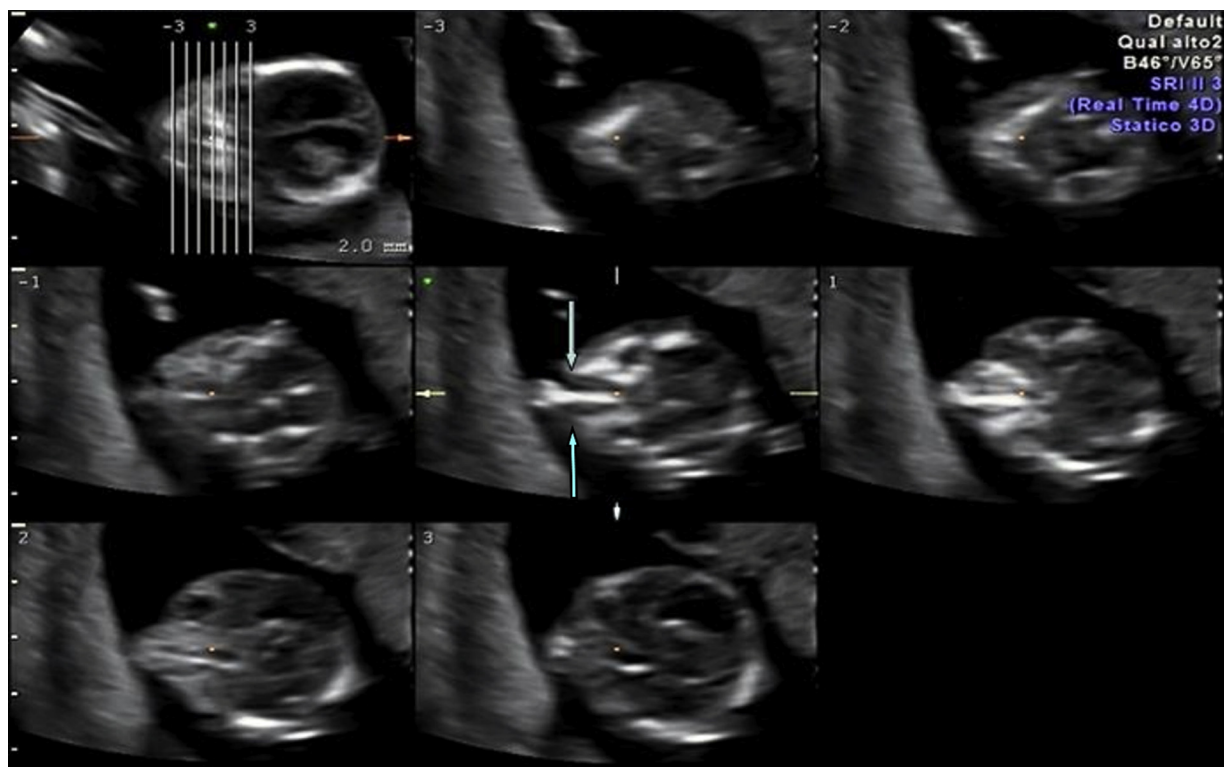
Tomographic ultrasound imaging of the fetal face (comprising the portion from the fetal orbits to the fetal chin), performed using thin (1-mm) slices, revealed median clefting (cleft lip plus cleft palate; marked by arrows).
